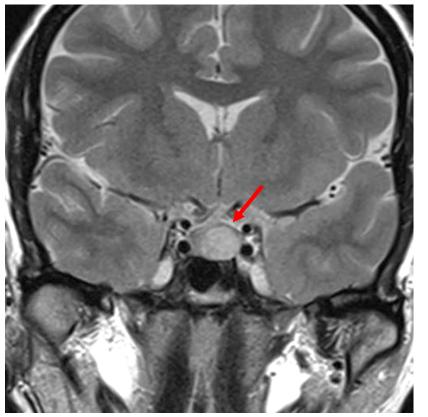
Typical macroadenoma (arrow) on a coronal T2-weighted image
